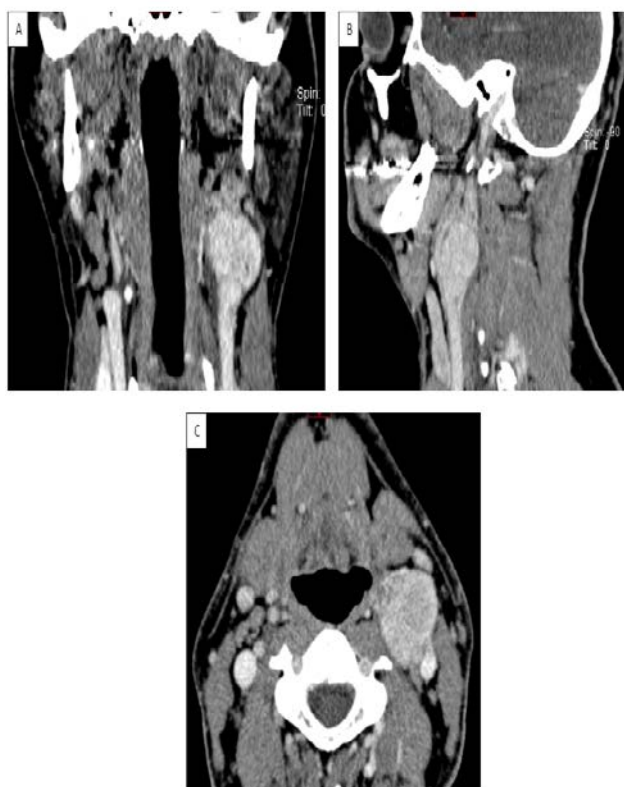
Multislice computed tomography findings of the neck: hypervascular expansive lesions at the level of bifurcation of common carotid artery which move the external and internal carotid arteries – carotid glomus.
